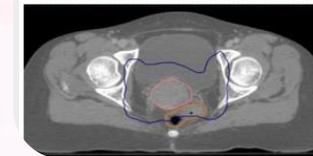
planning CT. The PTV is outlined in blue, CTV in red and rectum in yellow.
